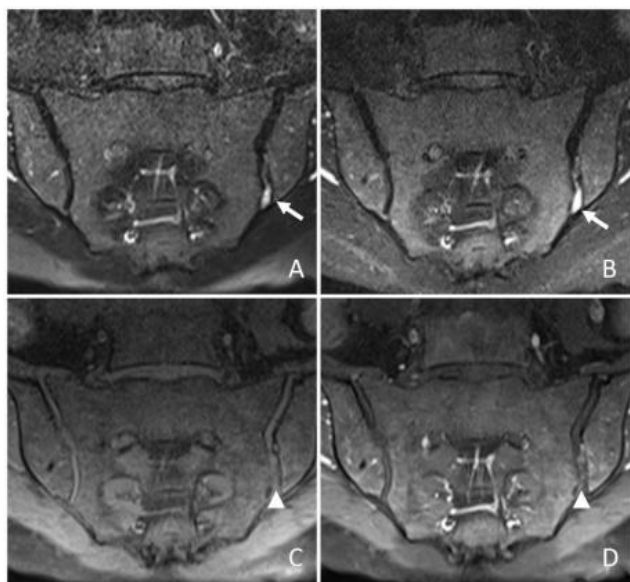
Coronal oblique fat-suppressed T2-weighted (A) and coronal oblique STIR; (B) MR images showed the left sacroiliac joint effusion (arrows) at the lower level; Coronal oblique fat-suppressed T1-weighted MR images obtained before (C), and after (D) the administration of paramagnetic contrast medium showed enhancement (arrowheads) at the left sacroiliac joint consistent with synovitis. There was no bone marrow oedema and joint irregularity
